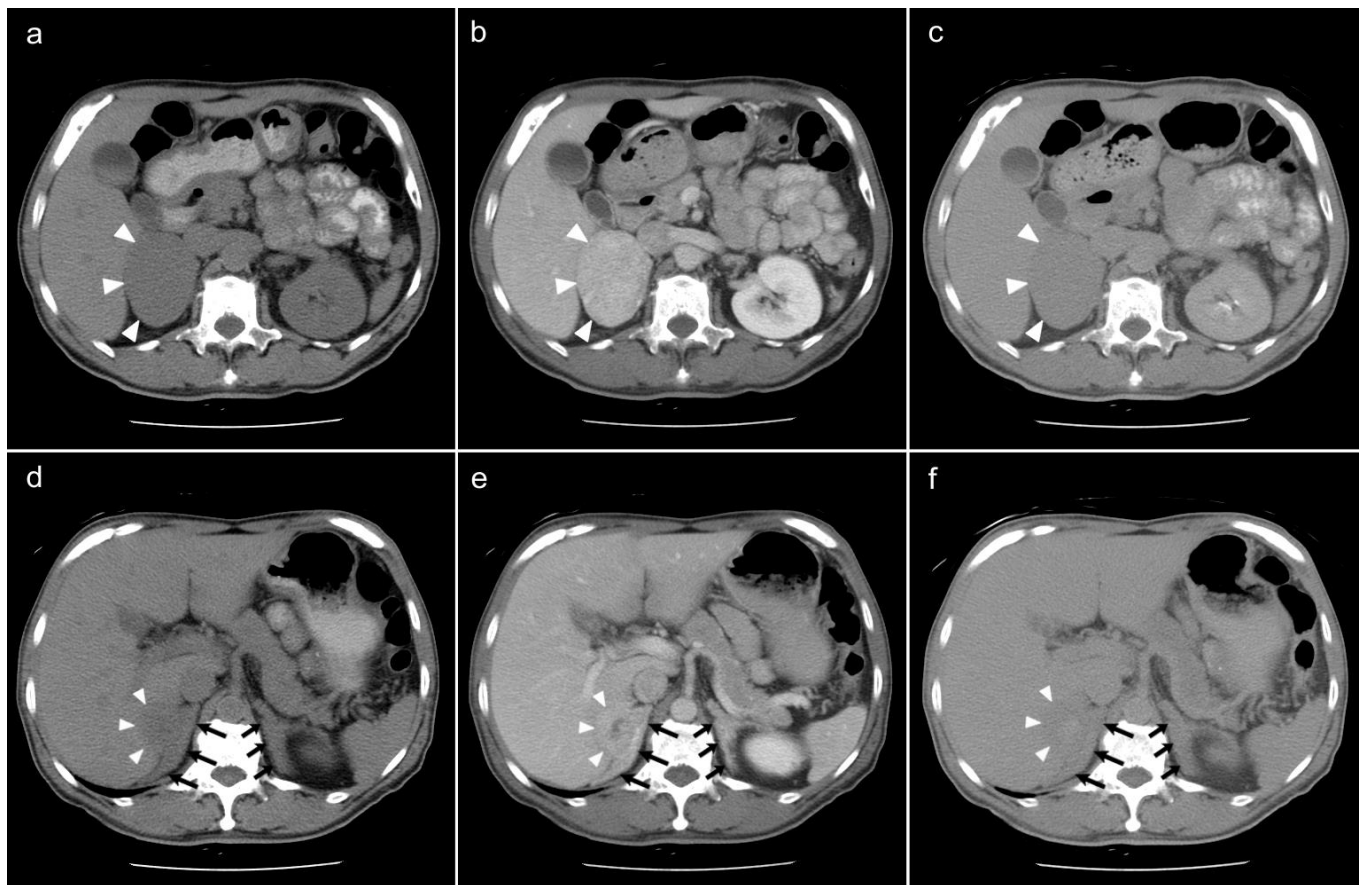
Computed tomography images of the adrenals of a 64 year old phenotypic male with 46XX karyotype affected by congenital adrenal hyperplasia.
